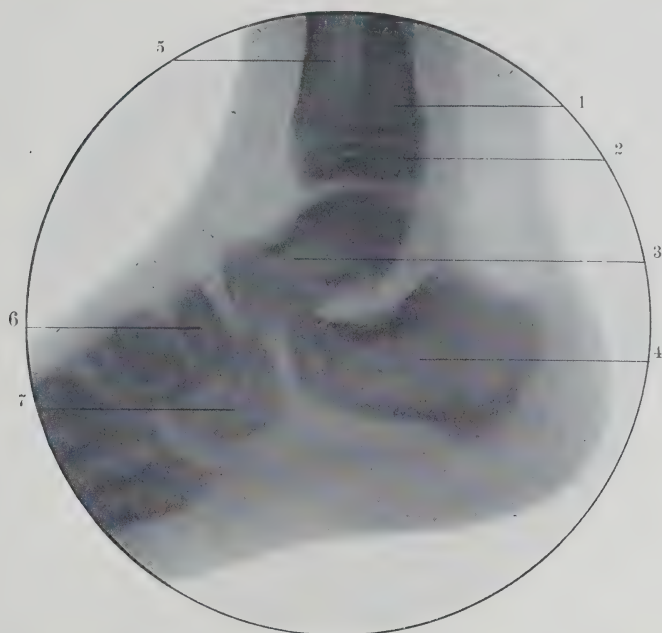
Radiograph Showing Lateral View of Ankle at Seven Years. 1, Superimposed shadow of fibula; 2, lower epiphysis of tibia; 3, astragalus; 4, os calcis; 5, tibia; 6, scaphoid; 7, cuboid. (Original.)
